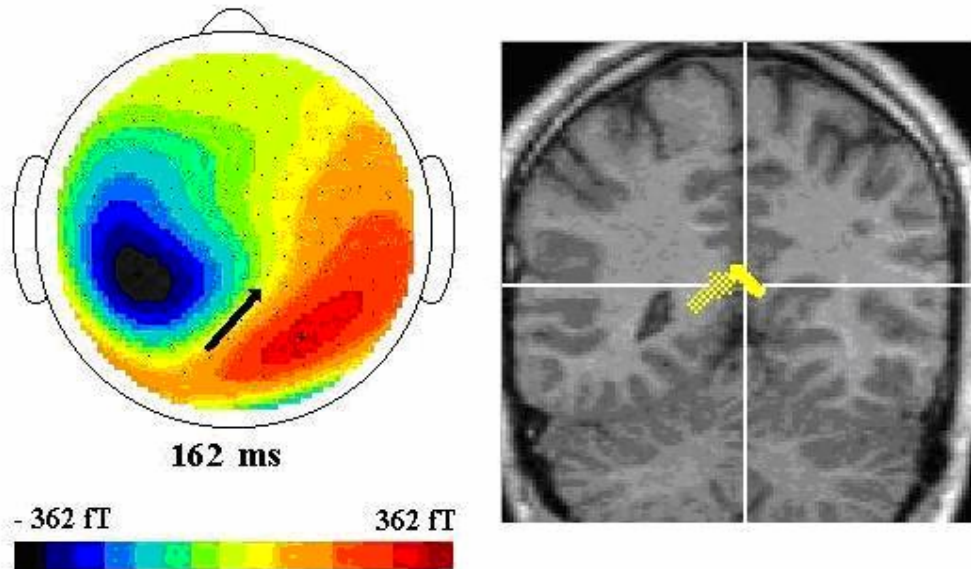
Field and source analyses On top, the map is constructed 162 ms after applying a visual stimulus. The ECD is presented by the black arrow. An advanced analysis (bottom) of the same field, now with the MRI image, shows that this single ECD is comprised of two ECDs closely together. (Data provided by the author.)
